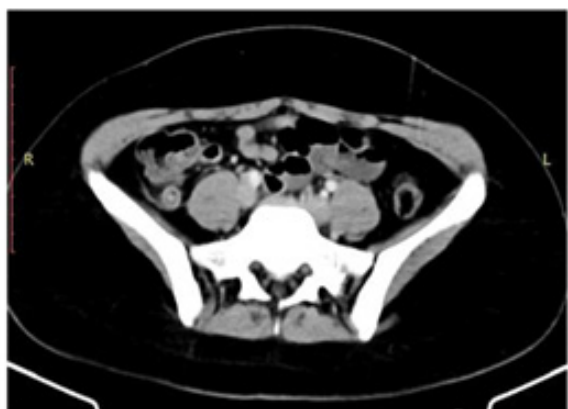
thick enhancing appendiceal wall with Appendicolith.Fig. 2: CT with IV contrast showing Appendicolith, smudging and Peri-appendiceal collection.
